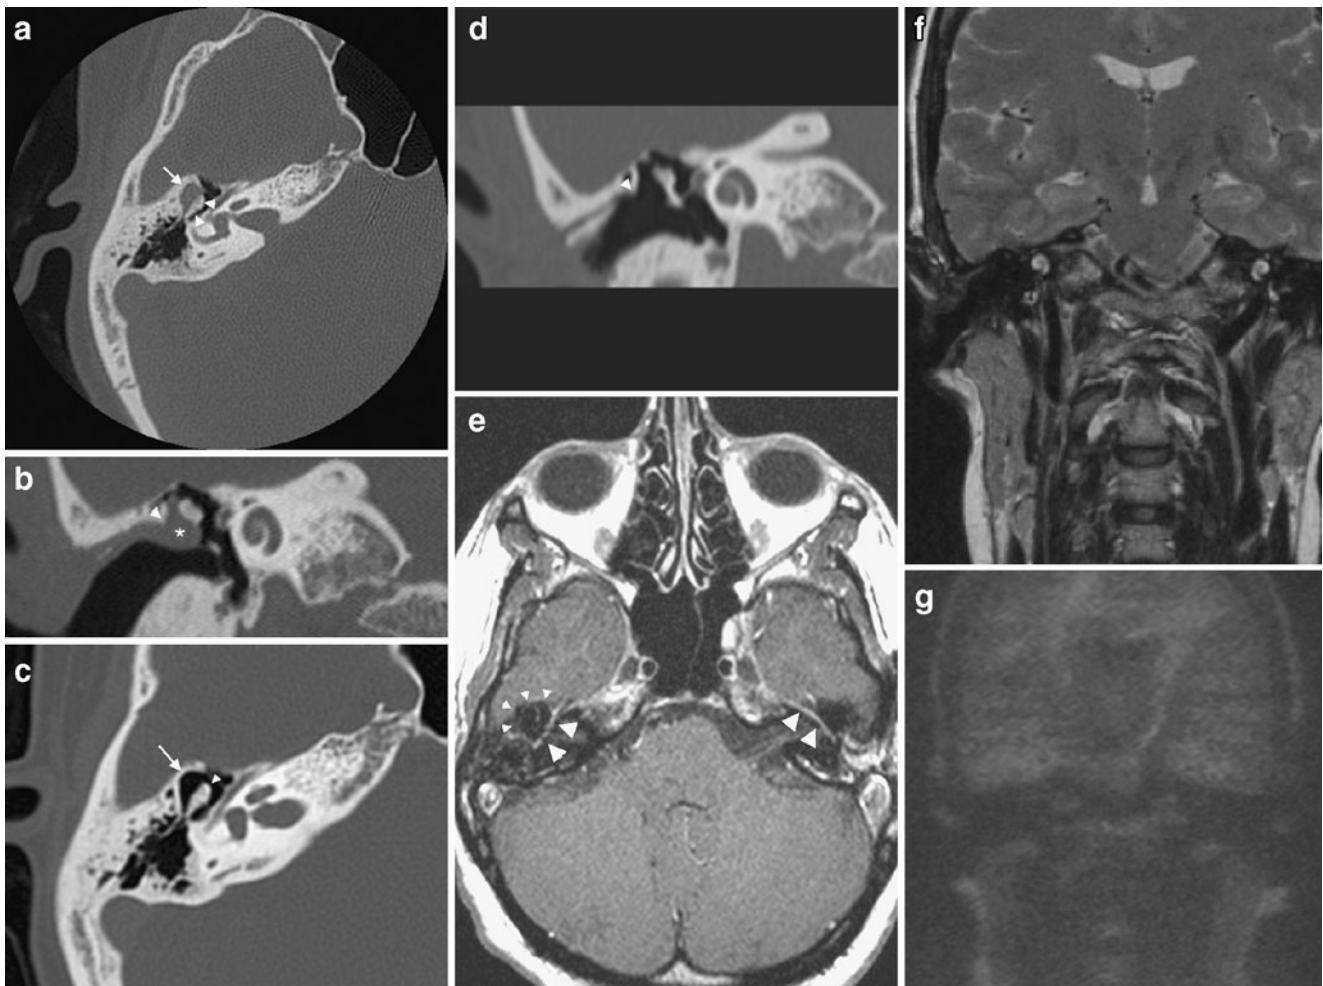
A 32-year-old woman examined because of right-sided conductive hearing loss. At otoscopy, a cholesteatoma is suspected in a retraction pocket at the pars flaccida on the right side. a Axial CT image at the level of the malleus head, incus body, and short process. Soft tissues can be seen in Prussak's space with erosion of the lateral epitympanic wall (*arrow*), the malleus head, and incus body (*arrowheads*). b Coronal CT reformation at the level of the cochlea. There is a nodular soft tissue in Prussak's space (*asterisk*) with amputation of the scutum (*arrowhead*). c Axial CT image at the level of the malleus head, incus body, and short process (same level as a). CT examination performed 1 year after the CT examination in a. The soft tissues as seen in a can no longer be seen. The results of the erosion are, however, still visible: erosion of the lateral epitympanic wall (*arrow*) and the malleus head (*arrowhead*). This image is pathognomonic of an auto-evacuated cholesteatoma: the cholesteatoma sac has opened and evacuated its content through the external auditory canal. d Coronal reformation at the level of the cochlea (same level as b). CT examination performed 1 year after the CT examination in b. The soft tissues in Prussak's space as seen in b can no longer be seen. The amputation of the scutum can, however, still be seen (*arrowhead*). Again, this image is typical of an auto-evacuated cholesteatoma sac. e Axial delayed post-gadolinium T1-weighted image at the level of the middle ear (same level as a and c, same date of acquisition as c). The tympanic segment of the facial nerve can be seen
